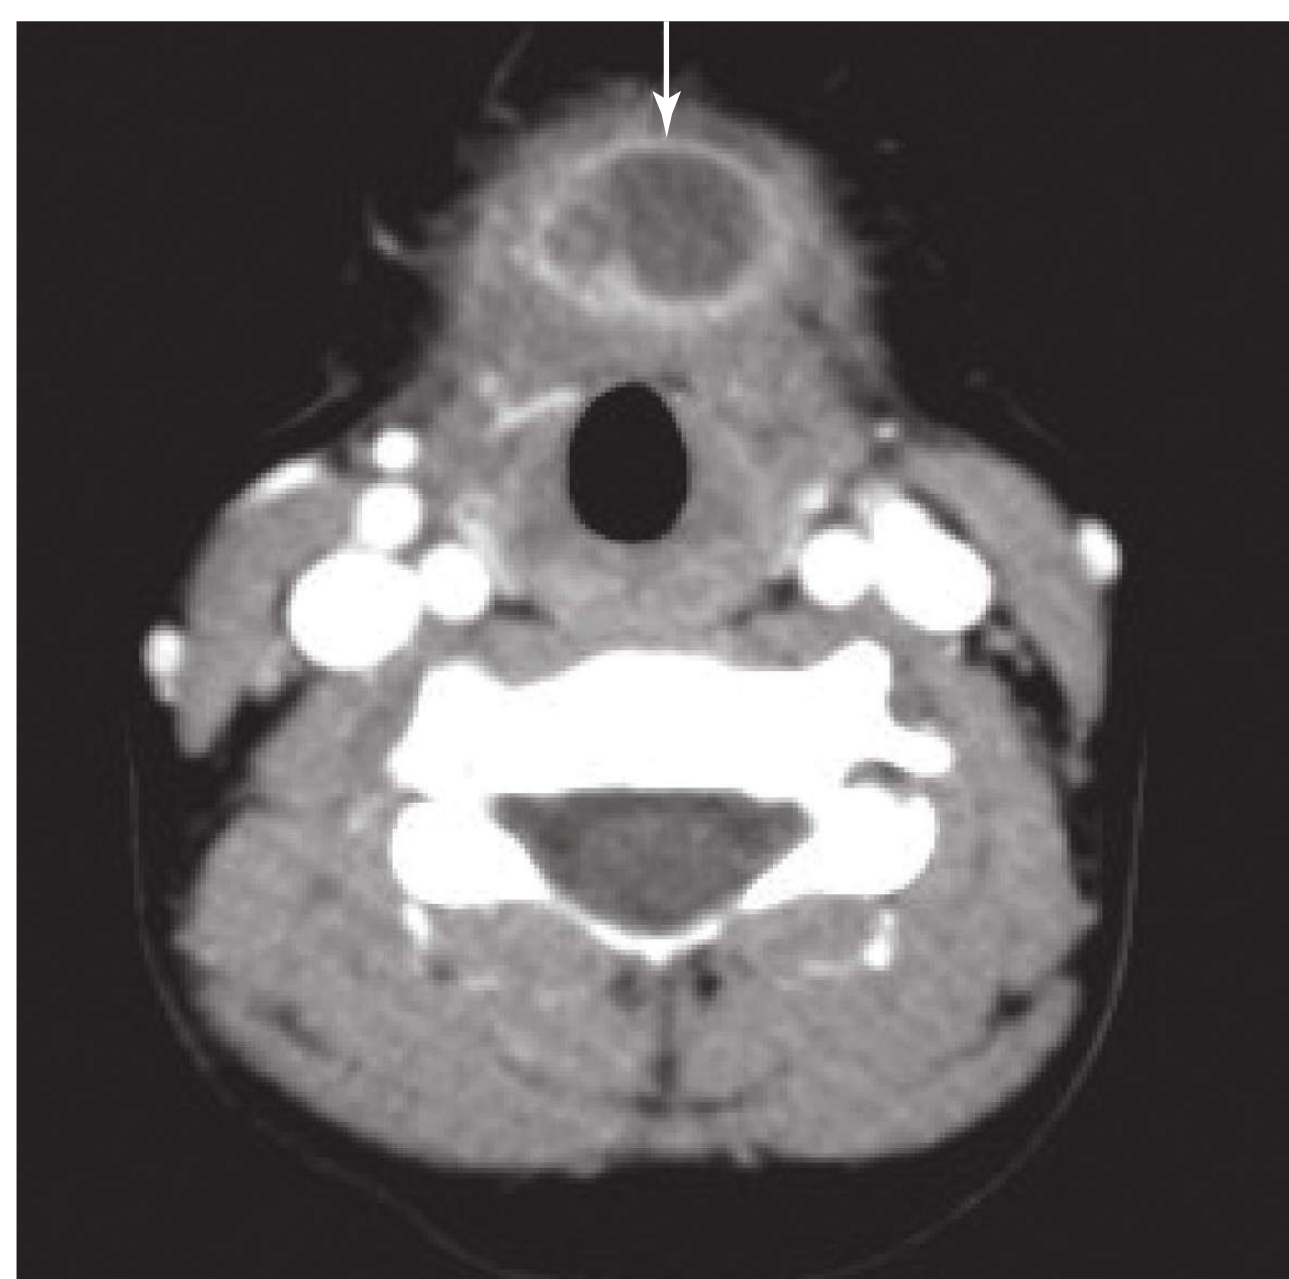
■ Thyroglossal Duct Cyst. CT of the neck showing anterior thyroglossal duct cyst. (Photo contributor: Lawrence B. Stack, MD.)
